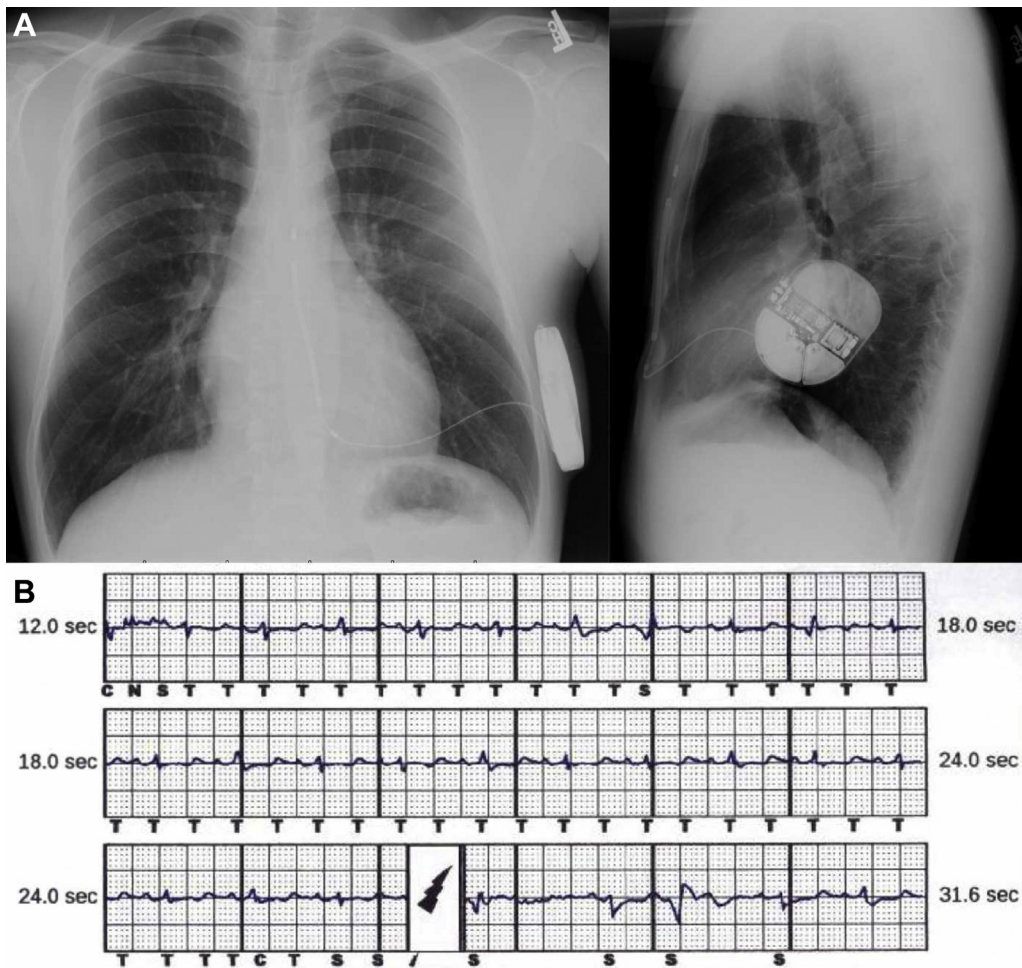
A: Posteroanterior and lateral chest radiograph of the subcutaneous implantable cardioverter-defibrillator with electrode in the left parasternal subcutaneous location. B: Stored electrogram tracing of an inappropriate shock due to T-wave oversensing.
